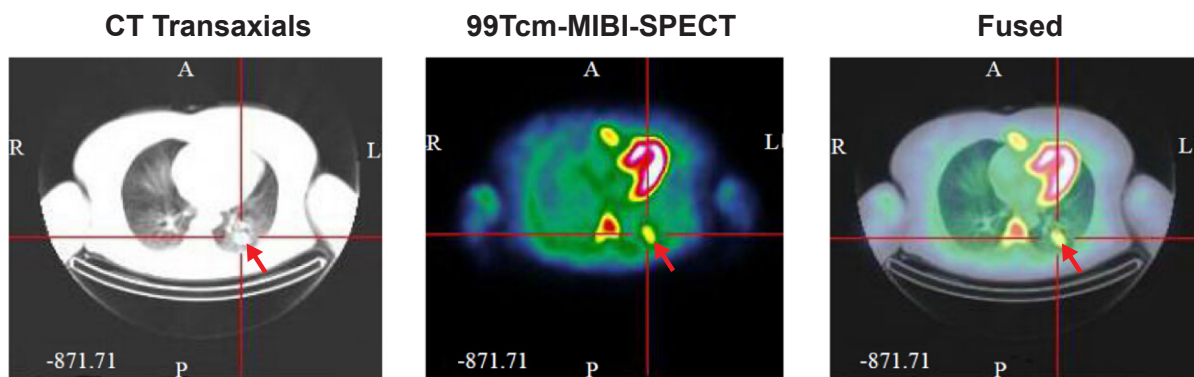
Imaging findings using ⁹⁹Tcm-MIBI SPECT of a 49-year-old female patient with malignancy. The lesion was pathologically diagnosed as metastatic lymph node.
